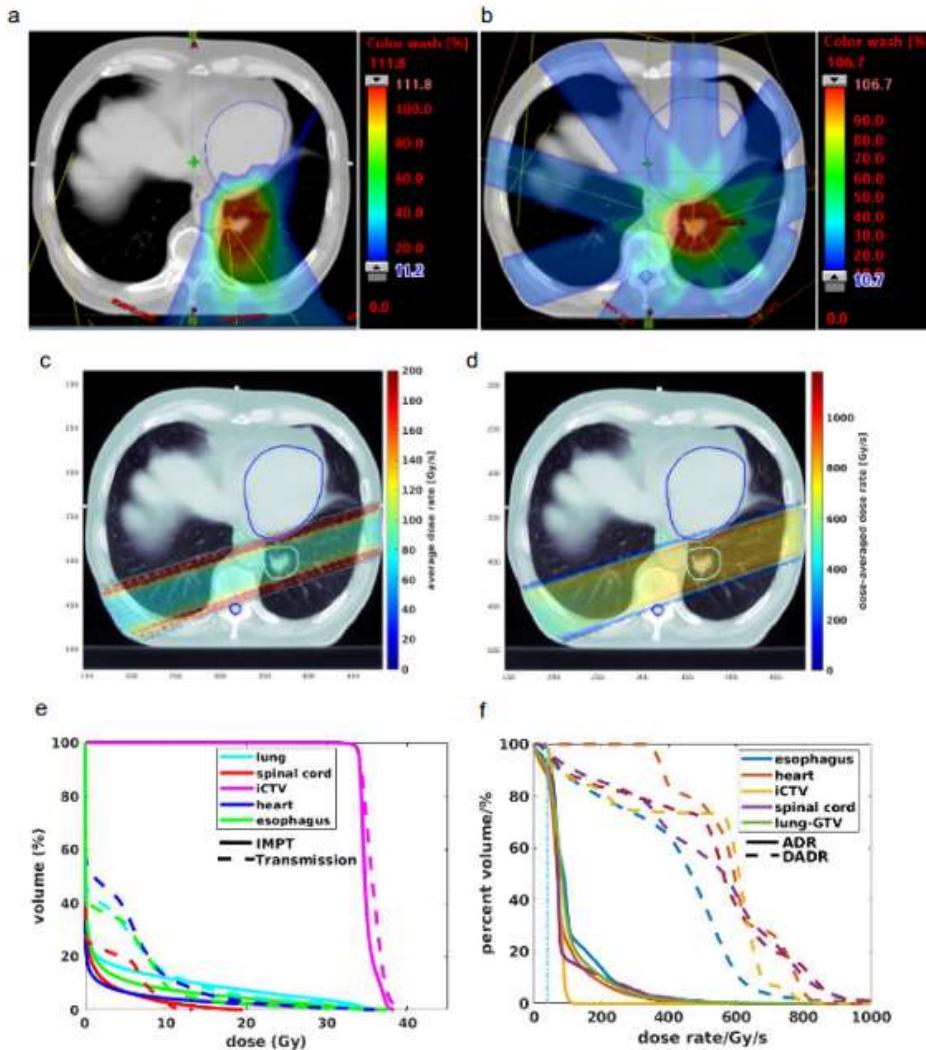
(a) An IMPT plan dose color wash superimposed on a CT slice. (b) A transmission plan dose color wash superimposed on the same CT slice. (c) One field of ADR distribution superimposed on the CT slice. (d) The same field of DADR distribution superimposed on the CT slice. (e) The averaged IMPT and transmission plans' DVHs of the 7 patients. (f) An example of the dose rate volume histogram (DRVH) of one patient's transmission plans using ADR and DADR methods.
